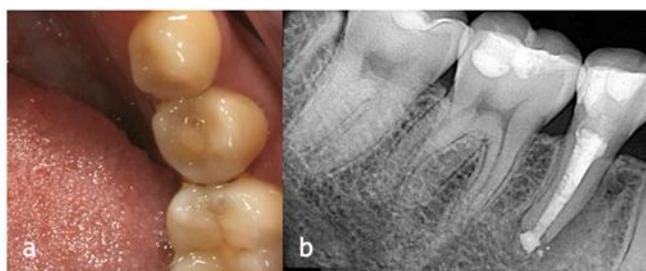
(a,b) Clinical and radiograph after treatment
